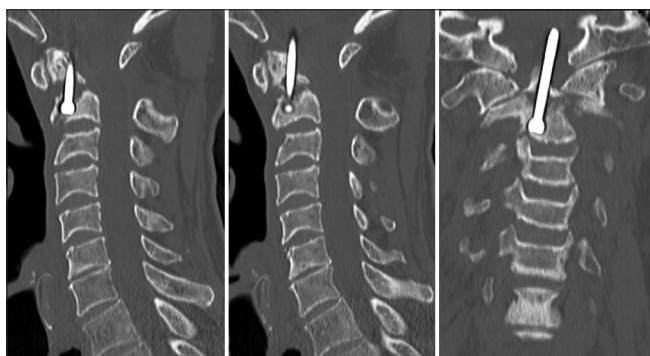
Sagittal and coronal computed tomography images of the cervical spine 7 months after anterior odontoid screw fixation demonstrating upward migration of the patient's odontoid screw.
